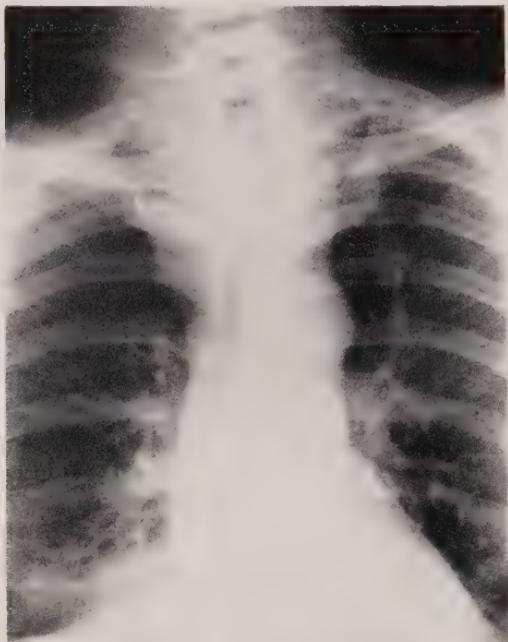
X-ray of dumbbell type of intrathoracic goiter compressing trachea at thoracic inlet.
